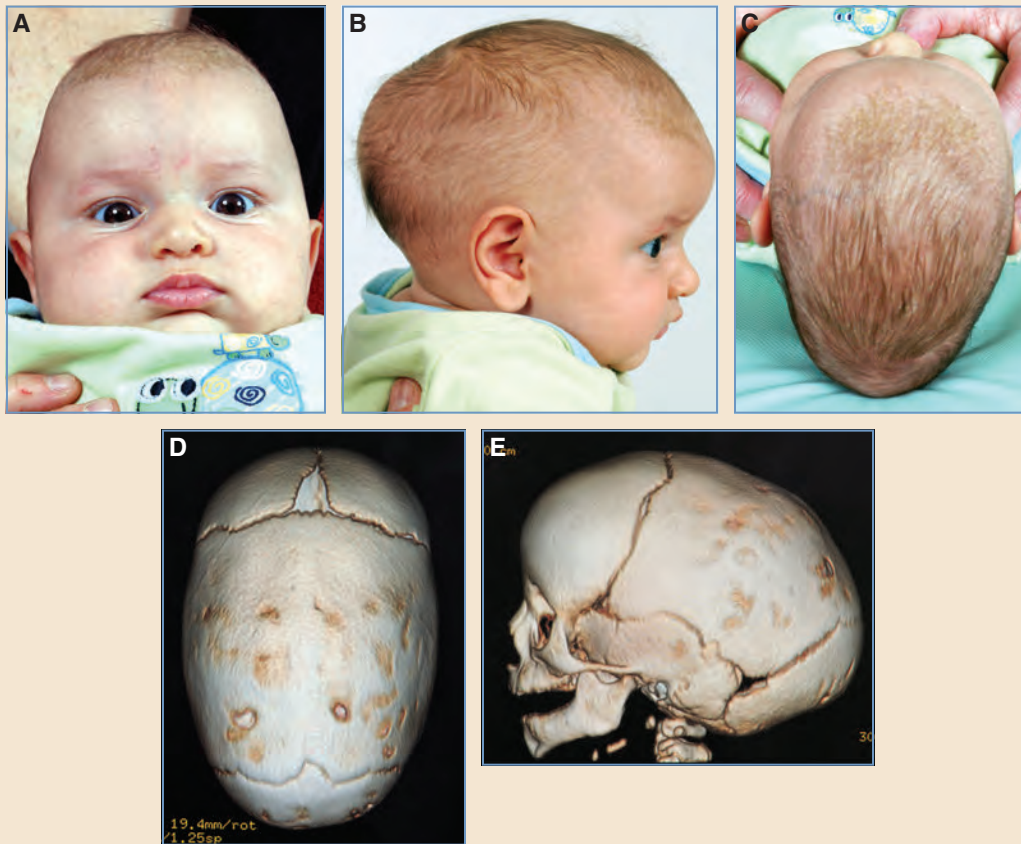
This infant has sagittal synostosis. A-C, Forehead bossing, bitemporal and biparietal narrowing, prominence of the occipital region, and elongation of the head. D and E, In addition to the characteristics identified clinically, CT revealed the fusion of the sagittal suture.
